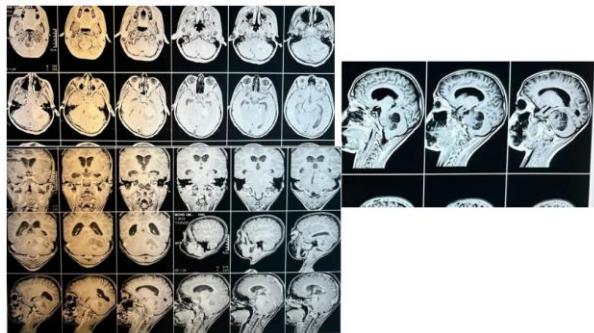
Pre op MRI with contrast
